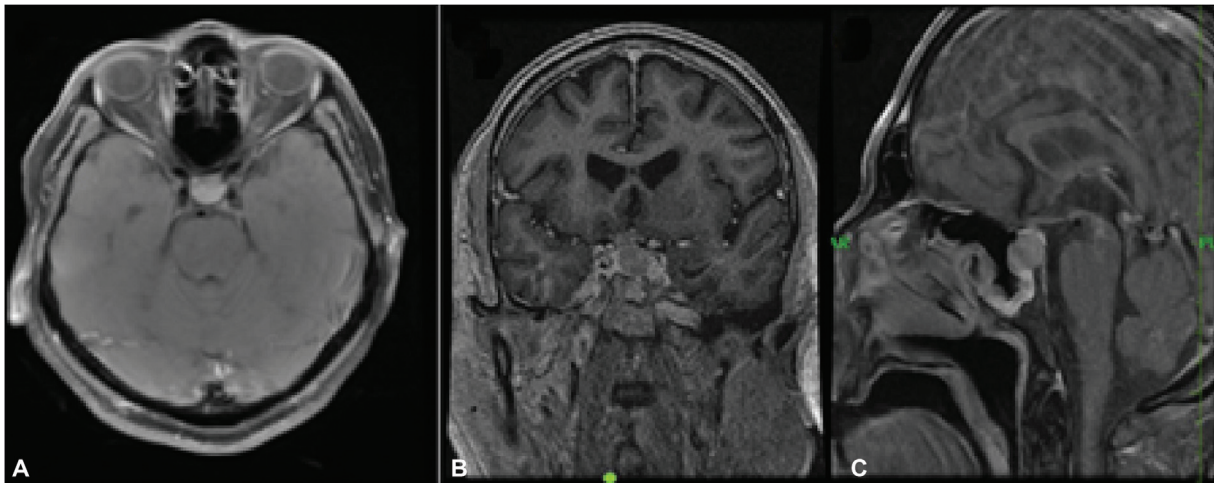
Magnetic resonance imaging (MRI) brain contrast pituitary macroadenoma with suprasellar extension.
